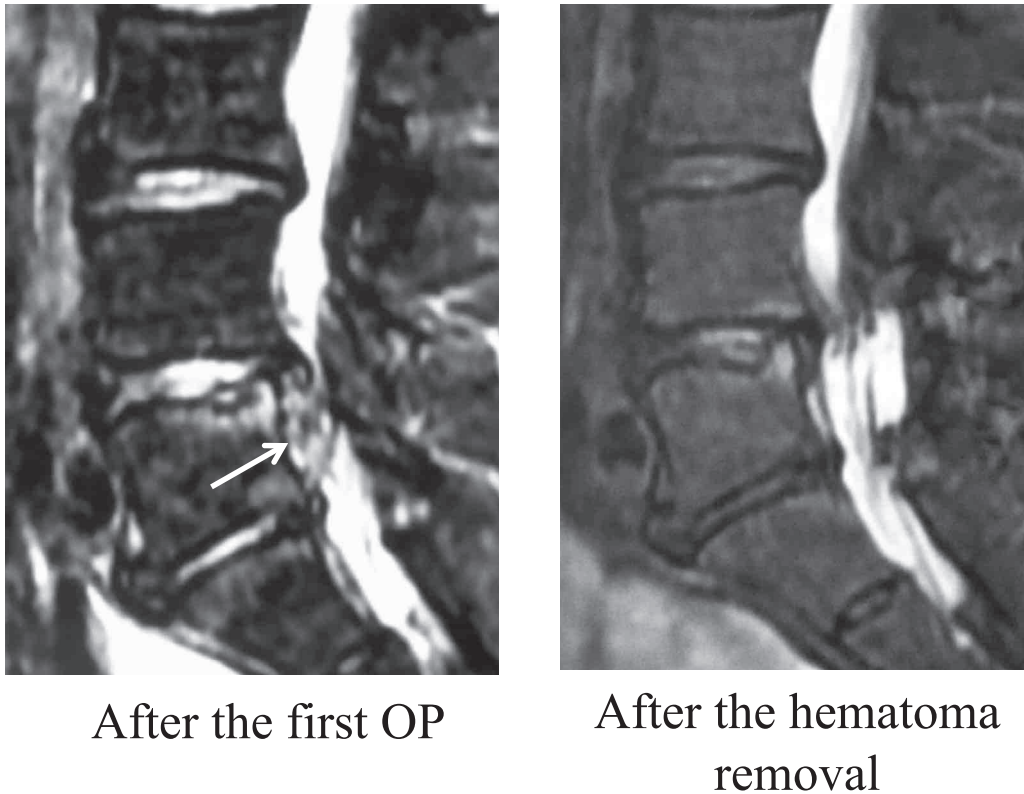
MRI after the initial and second surgery. Note the epidural hematoma (left) and its removal (right).
